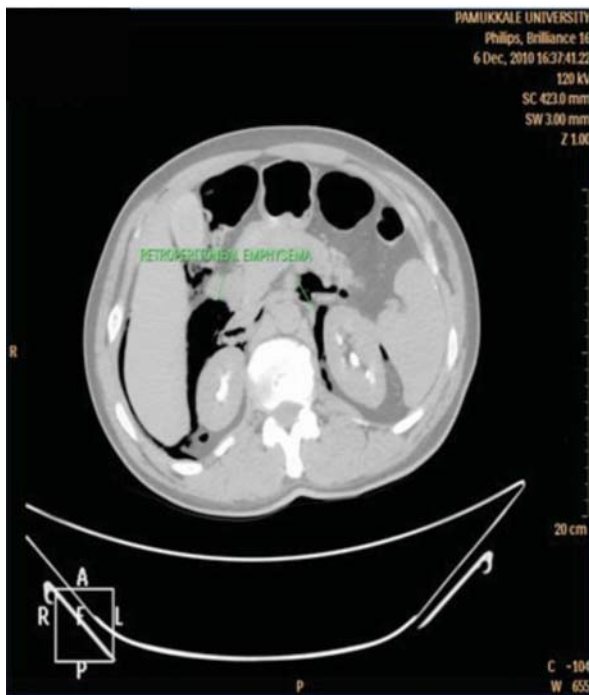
CT demonstrate retroperitoneal free air.
